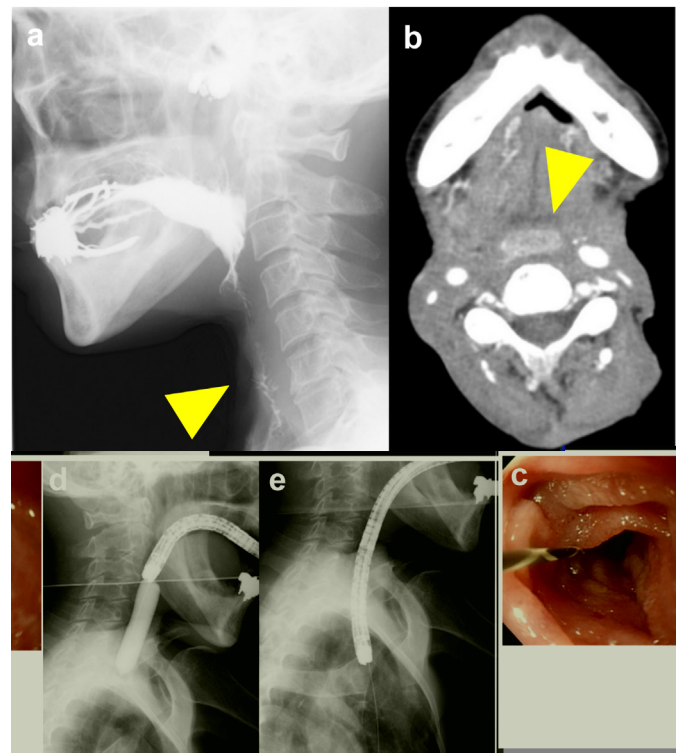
(a) Gastrografin fluoroscopy showing complete obstruction caused by spasmodic contraction of the free jejunum (arrowhead). (b) Contrast-enhanced computed tomography (CT) showed good enhancement of the free jejunum (arrowhead). (c) The endoscope was inserted into the stomach smoothly without resistance. (d, e) Dilatation of the anastomotic site and jejunal graft was performed without obstruction.
